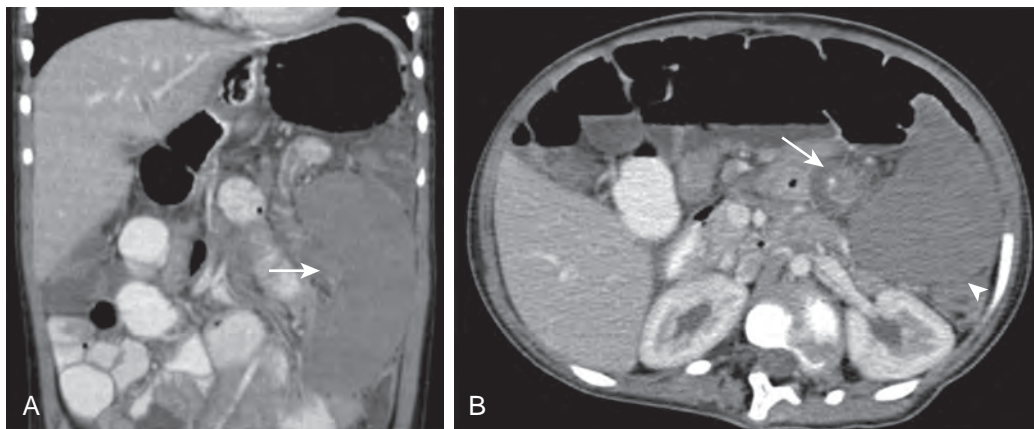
Splenic torsion. A. Torsion of the wandering spleen demonstrates absence of enhancement (arrow) on this contrast-enhanced CT coronal reformation. B. Note the whorled appearance of the splenic hilar vessels (arrow) and the lack of enhancement of the spleen parenchyma.
